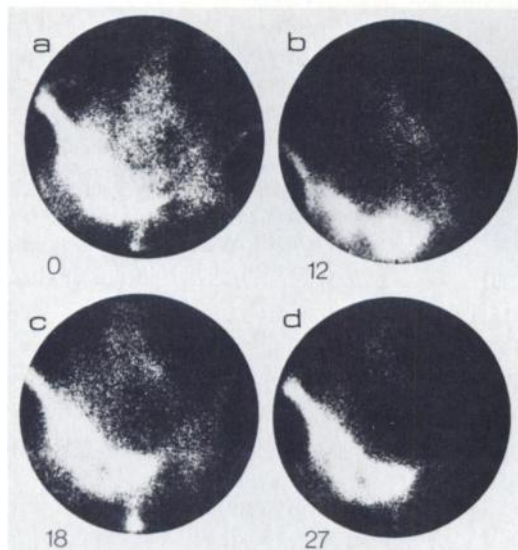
Anterior scintigrams of Patient 28. (a) Before treatment: High activity in right hemipelvis, consistent with Paget's disease. (b) After 1 yr of treatment: Improvement is obvious and score has dropped from 5 to 3. (c) After 18 mo of treatment: Activity in right hemipelvis has increased slightly but distinctly. Biochemical parameters remained normal. (d) After treatment was stopped: Alkaline phosphatase level also started to rise, and scintigraphic deterioration increased to Score 4.
